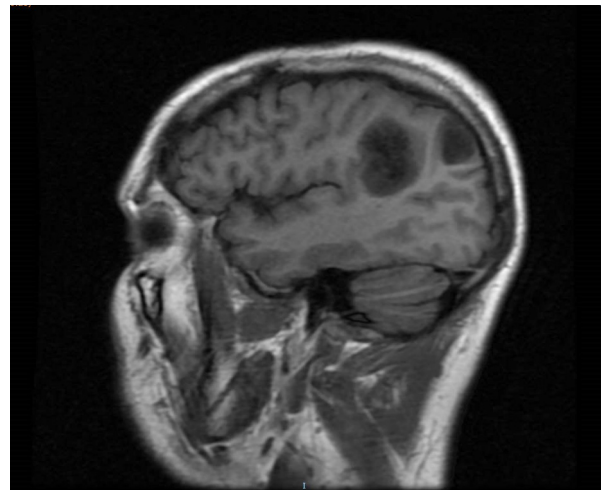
Preoperative MRI, T1 axial sequence. In all the MRIs performed during the preoperative study, 2 separate lesions were observed. In all studies, the radiological interpretation was low-grade gliomas.
